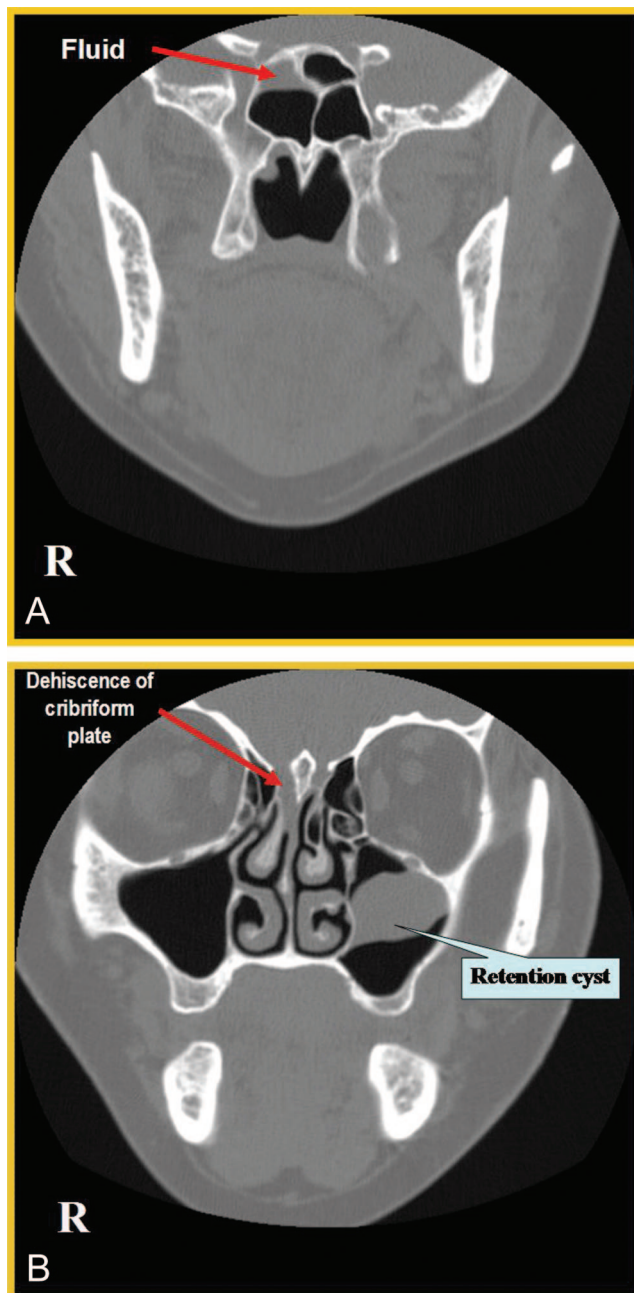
High resolution sinus CT scan showing (A) fluid in the right sphenoid sinus, and (B) cribriform plate dehiscence on the right side with apparent fluid collection adjacent to the middle turbinate and retention cyst in the left maxillary sinus.
